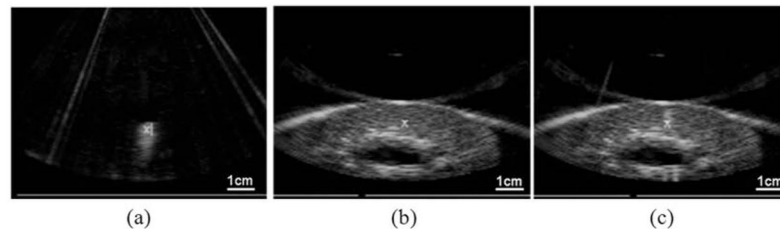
Ultrasound imaging of targeting and monitoring of histotripsy treatment using the 5 MHz imaging probe. Therapeutic ultrasound propagated from top to bottom of the images. (a) Prior to the treatment, a bubble cloud was generated in water and seen on ultrasound image as a hyperechoic region, which was marked as the treatment focus (“X”). (b) The focus marker was aligned with the targeted volume in the kidney on a pretreatment ultrasound image. (c) A bubble cloud was generated in the target volume to verify the target accuracy.
